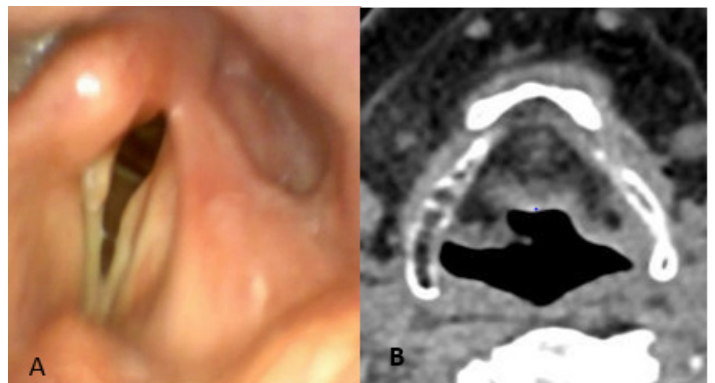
A: follow-up video-nasofibrolaryngoscopy 12 months after microlaryngeal surgery: normal-appearing vocal cords, supraglottis, and left piriform sinus with no tumor recurrence. B: axial contrast-enhanced CT image showing no evidence of tumor recurrence.
